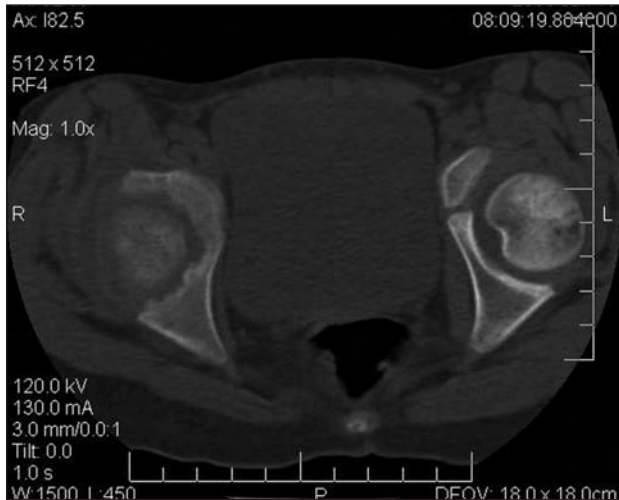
Computed tomography of the hip showing a diffuse protusion of the cavity of the right femoral head, besides an articular effusion with no signs of significant capsular thickening.
